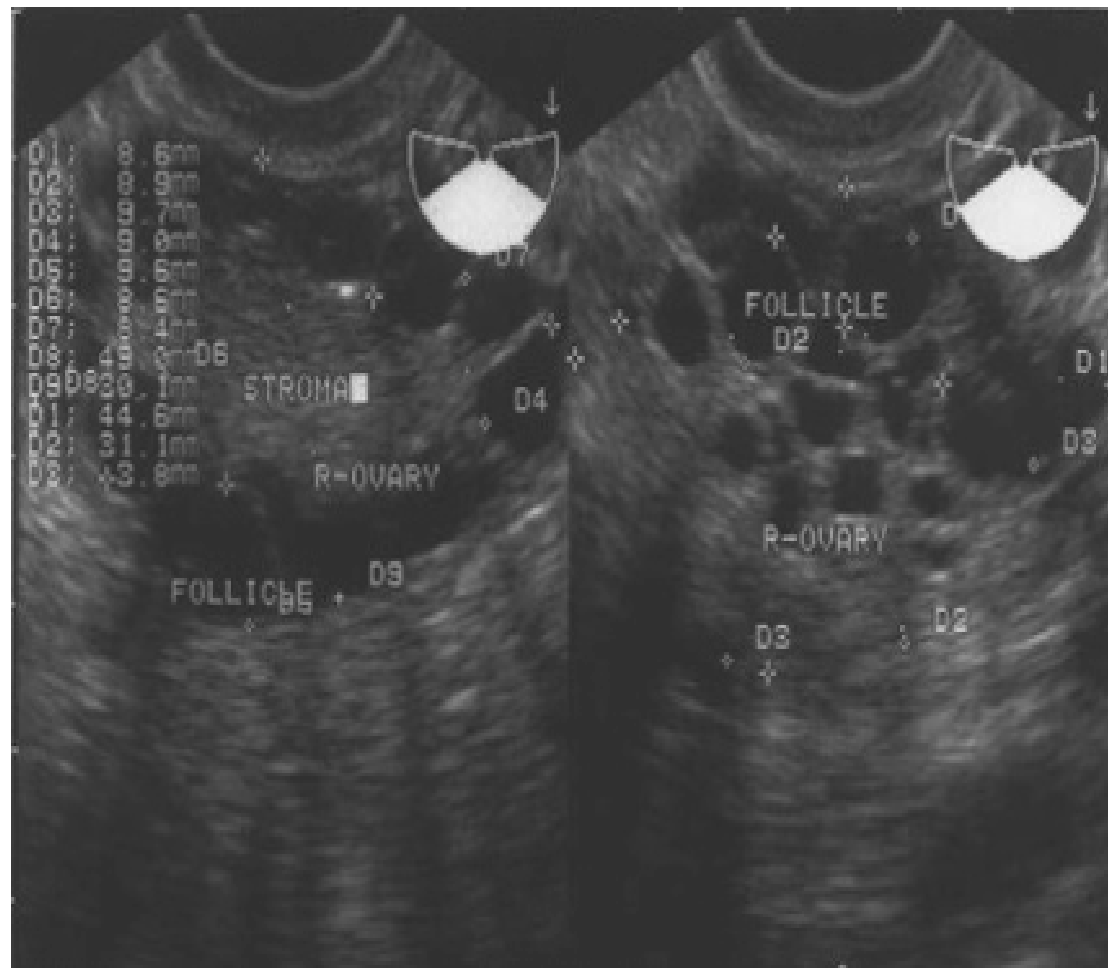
Transvaginal ultrasound depicting the right ovary of a 31-year-old woman with amenorrhea and polycystic ovary syndrome. The picture features major high-risk factors for the development of severe ovarian hyperstimulation syndrome: (1) “String of pearls” appearance of antral follicles on the left panel; (2) Dense stroma occupying the center of the ovary; (3) Enlarged ovary measuring 49×44.6 mm; (4) Total of 60 antral follicles in one ovary.
